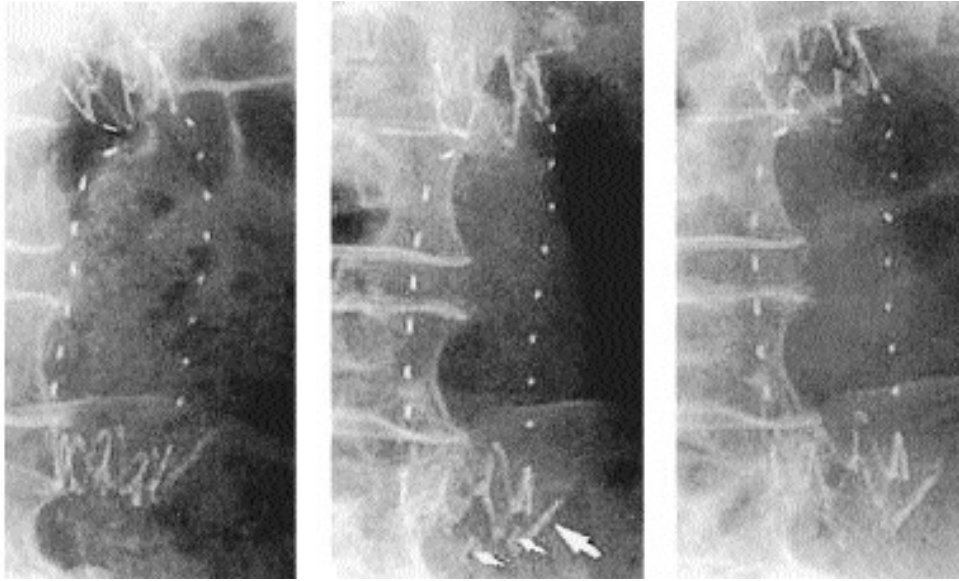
This series of plain radiographs taken at 6, 24, and 30 months (left to right) following endograft insertion show hook fractures (small arrows, middle) and proximal migration of the lower end of the stent graft (right). Aortic wall calcification serves as a migration marker (middle, large arrow). (From Brewster DC et al. *J Vasc Surg* 1998;27:992–1003, with permission.)
